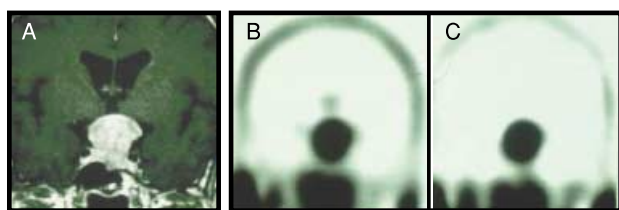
Neuroimaging findings in a 42-year-old male with non-functioning pituitary adenoma. Postcontrast T1-weighted coronal magnetic resonance image (A) shows a tumor in the pituitary region. Both early (B) and delayed (C) images of technetium-99m sestamibi single photon emission computed tomography show an intense accumulation corresponding to the lesion.
